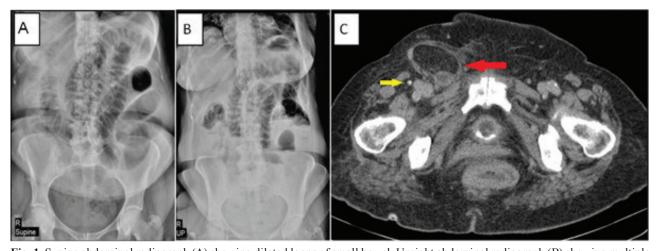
Supine abdominal radiograph (A) showing dilated loops of small bowel. Upright abdominal radiograph (B) showing multiple air-fluid levels in dilated small bowel, and air-fluid level in the stomach. CT of the abdomen (C), which was performed on admission, showing a fluid-containing structure in the Right groin, medial to the femoral vein and artery (Red arrow). The sac contains a small amount of extra luminal fluid and a loop of thickened, enhancing small bowel. Femoral artery and vein (medial to artery) is shown by yellow arrow.
